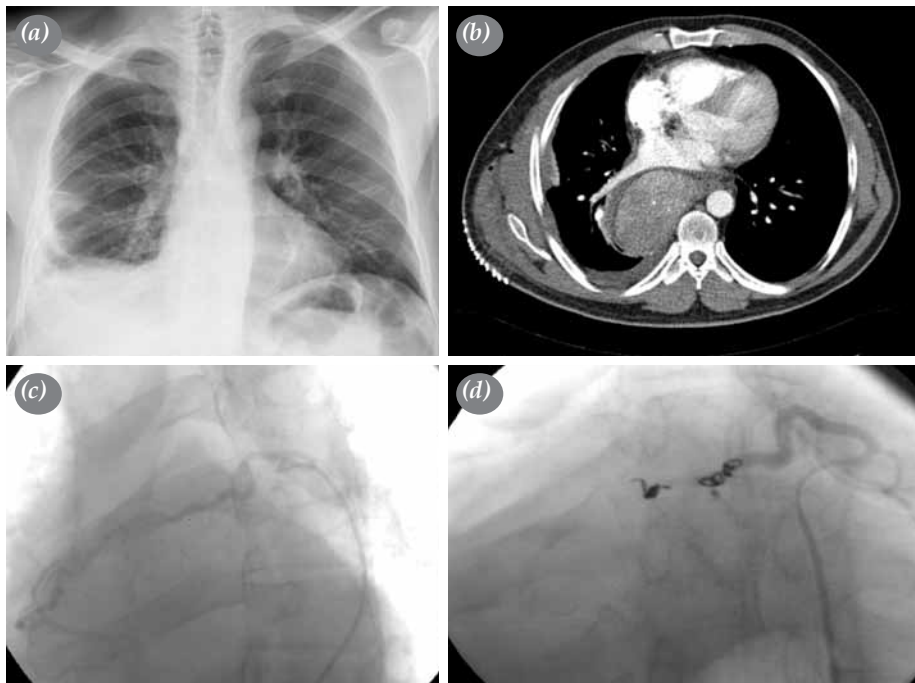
(a) A posteroanterior chest X-ray showing thickening of right minor fissure, blunt right costophrenic recess, linear densities at right lower zone, and closed right cardiophrenic angle. (b) A contrast-enhanced computed tomography scan showing a heterogeneous soft tissue mass at right paravertebral region, high density effusion at right posterior and at the right minor fissure. (c) Digital subtraction angiography showing a major feeding artery and its multiple branches feeding the mass. (d) No contrast enhancement was seen after coil and particle embolization (complete embolization) of the main feeding artery.
